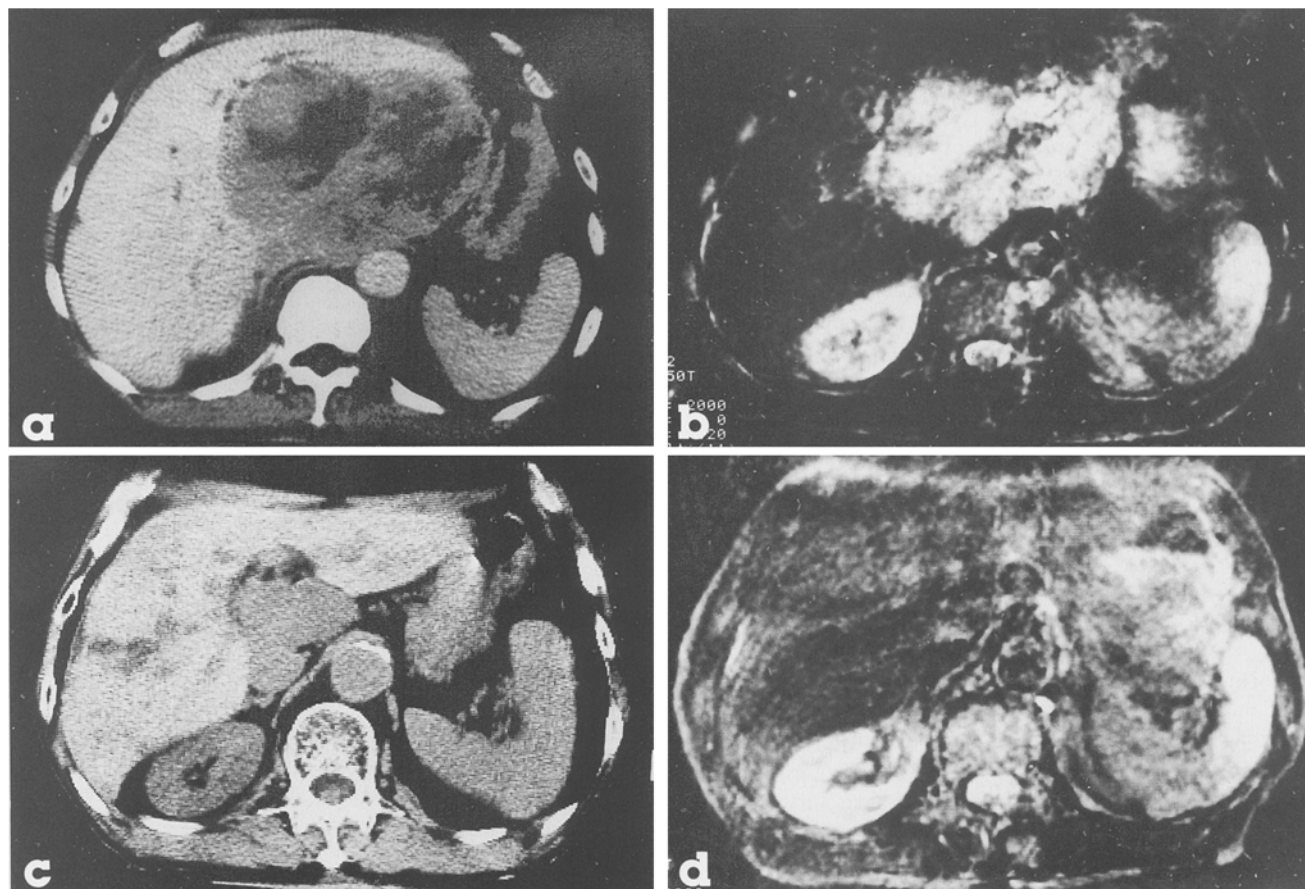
a–d. CT and MRI images obtained a, b prior to and c, d after EPF therapy in a 74-year-old man. a A large, inhomogeneous tumor is visible in the caudate lobe. The IVC is markedly depressed. b The tumor shows
